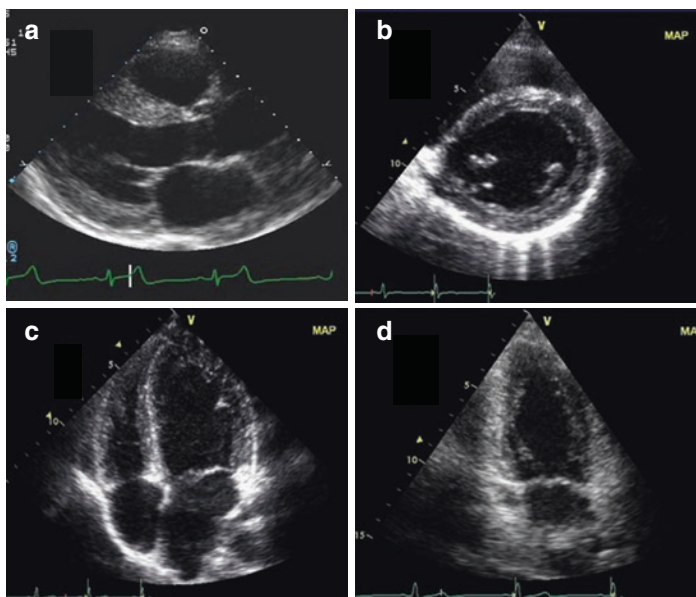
Traditional echocardiographic windows
